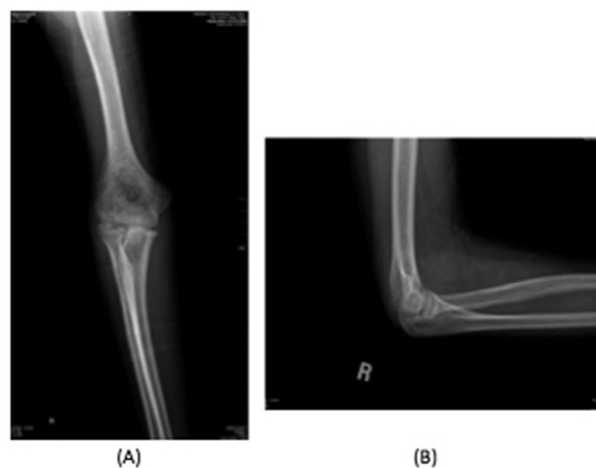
(A) Anteroposterior and (B) lateral plain radiographic films of the right elbow of patient 1 at 4 months after injury demonstrate degeneration and incongruity of the radiocapitellar joint.
